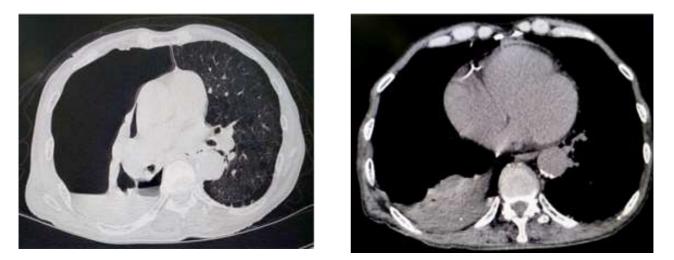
Chest CT scan. CT scan showed right hydropneumothorax with pleural effusion, a broncholith in the basal lobar bronchus.
